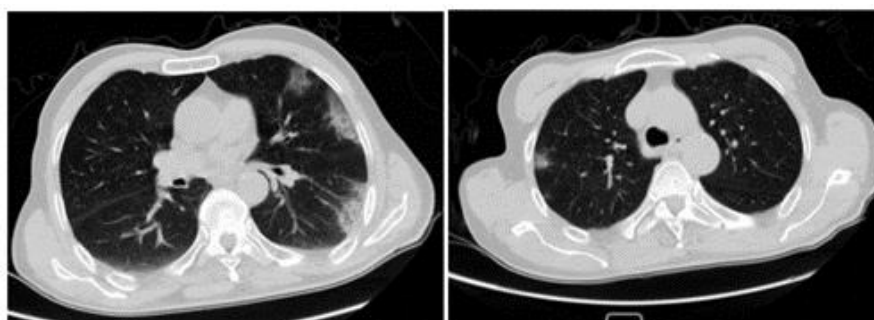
First case axial lung chest CT scan on hospital day 1
